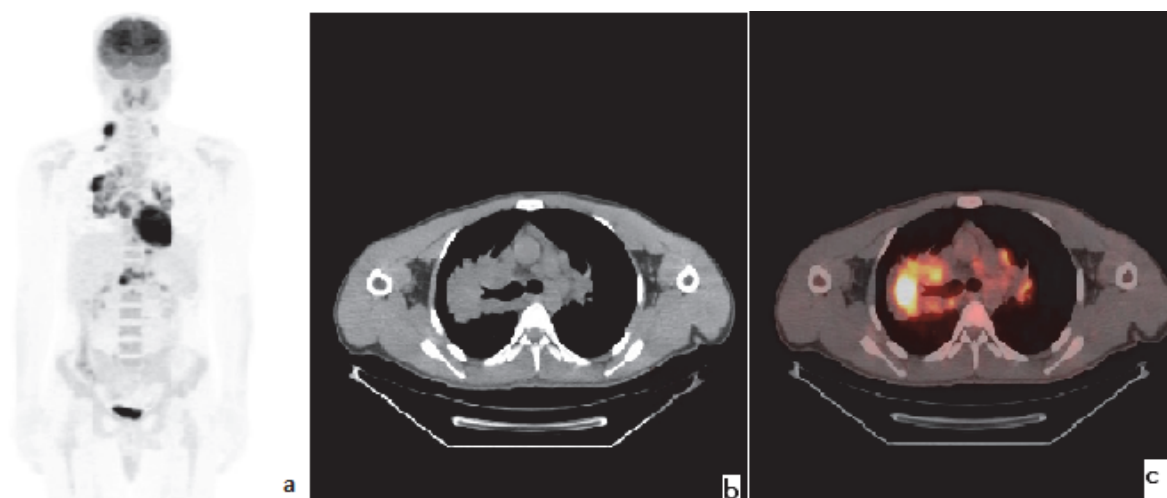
FDG PET of a 28-year-old male patient with diagnosis of sarcoidosis, demonstrates widespread involvement of right supraclavicular, bilateral mediastinal and abdominal multiple lymph nodes that mimicking lymphoma on Maximum Intensity Projection (MIP) images (a). Thoracic axial CT (b) and PET/CT fusion (c) images of same patient shows parenchymal lung lesion located in the central area of right lung, that can lead to false-positive results in terms of lung cancer.
